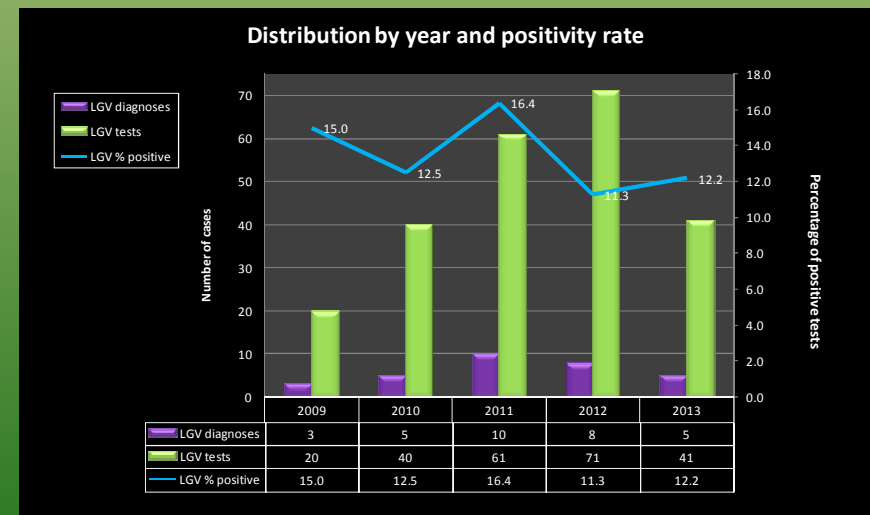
Distribution by year of LGV-suggestive cases in CT-DNA positive patients tested with LGV PCR and positivity rate.
